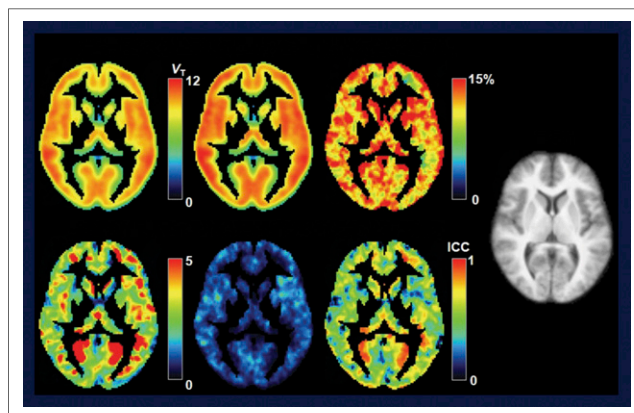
^{11}C -NOP-1A PET accurately assessed nociceptin/orphanin FQ peptide receptors in healthy human brain. Top row, left to right: test, retest, and retest variability. Bottom row, left to right: mean of summed squares between subjects, mean of summed squares within subjects, and test reliability. Right: MR imaging.
